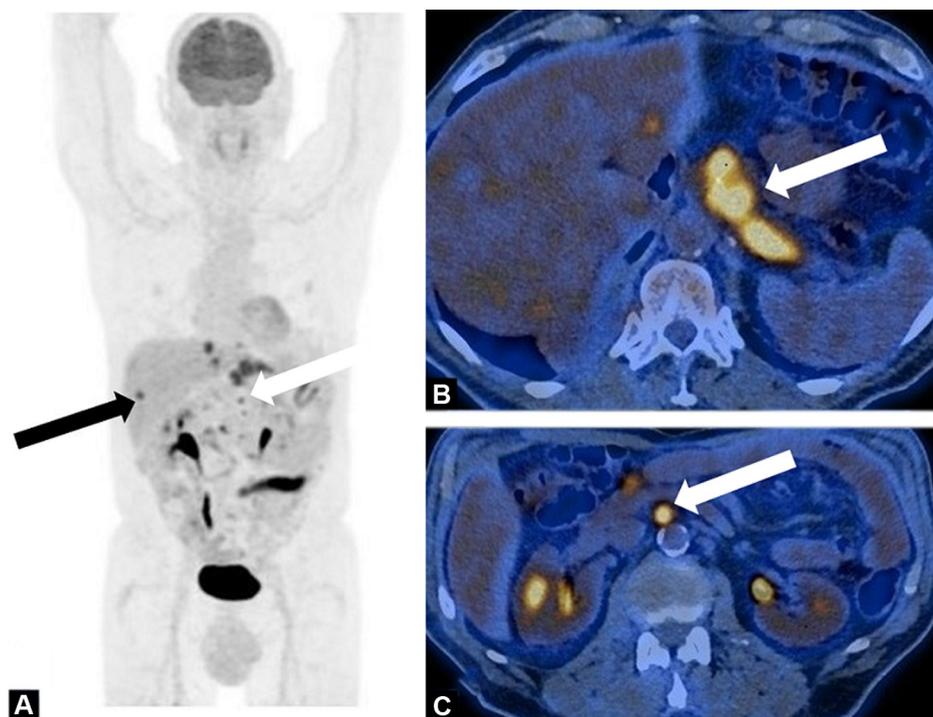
67-year-old man with pancreatic ductal adenocarcinoma at initial staging. Maximum intensity projection (A) and fused transaxial 18F-fluorodeoxyglucose PET/CT (B, C) images show hypermetabolic para-aortic lymph node (white arrows) and liver metastases (black arrow). Standardized uptake value (SUV max) of pancreatic adenocarcinoma is 9. (Acknowledgments Mathieu Gauthé. Department of Nuclear Medicine, Tenon Hospital, Paris France).
